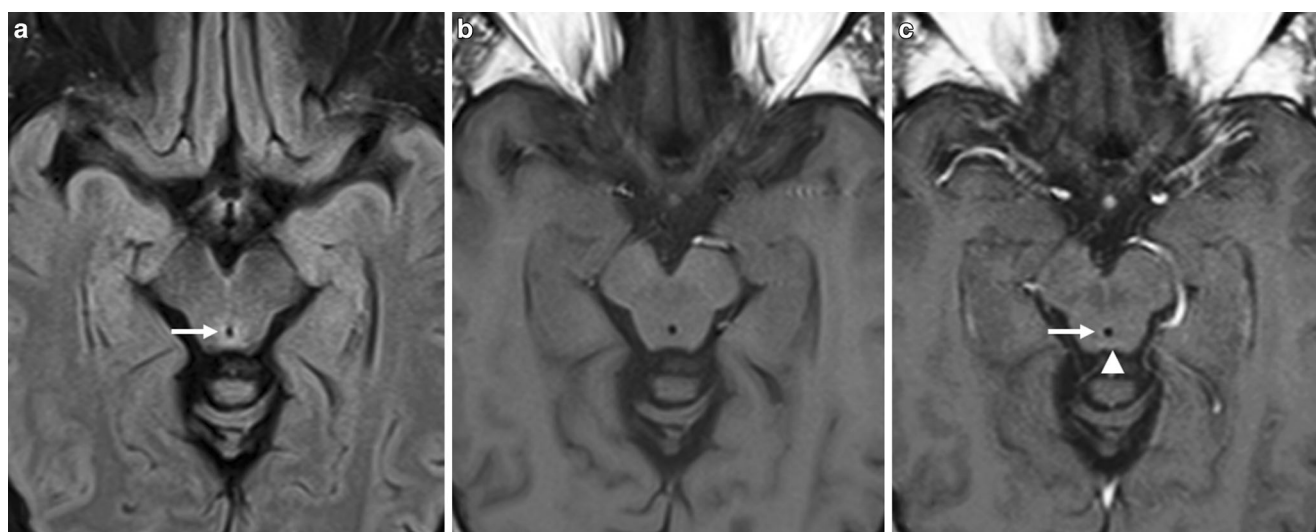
Axial fluid attenuated inversion recovery (FLAIR) image (a) showing a periaqueductal hyperintense lesion with blurred margins and involvement of the medial and paramedial quadrigeminal plate (*arrow*); b, c axial postcontrast (pc) T1WI (c) disclosing slight periaqueductal (c, *arrow*) and tectal (*arrowhead*) contrast enhancement (CE)
